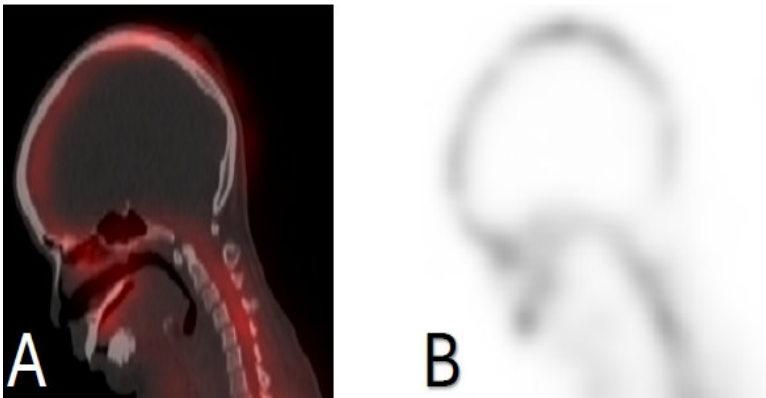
Fused SPECT-CT (A) and SPECT (B) images of the head and neck (sagittal view). Absent tracer uptake was noted in the mandibular area. Bone resorption with lytic changes
